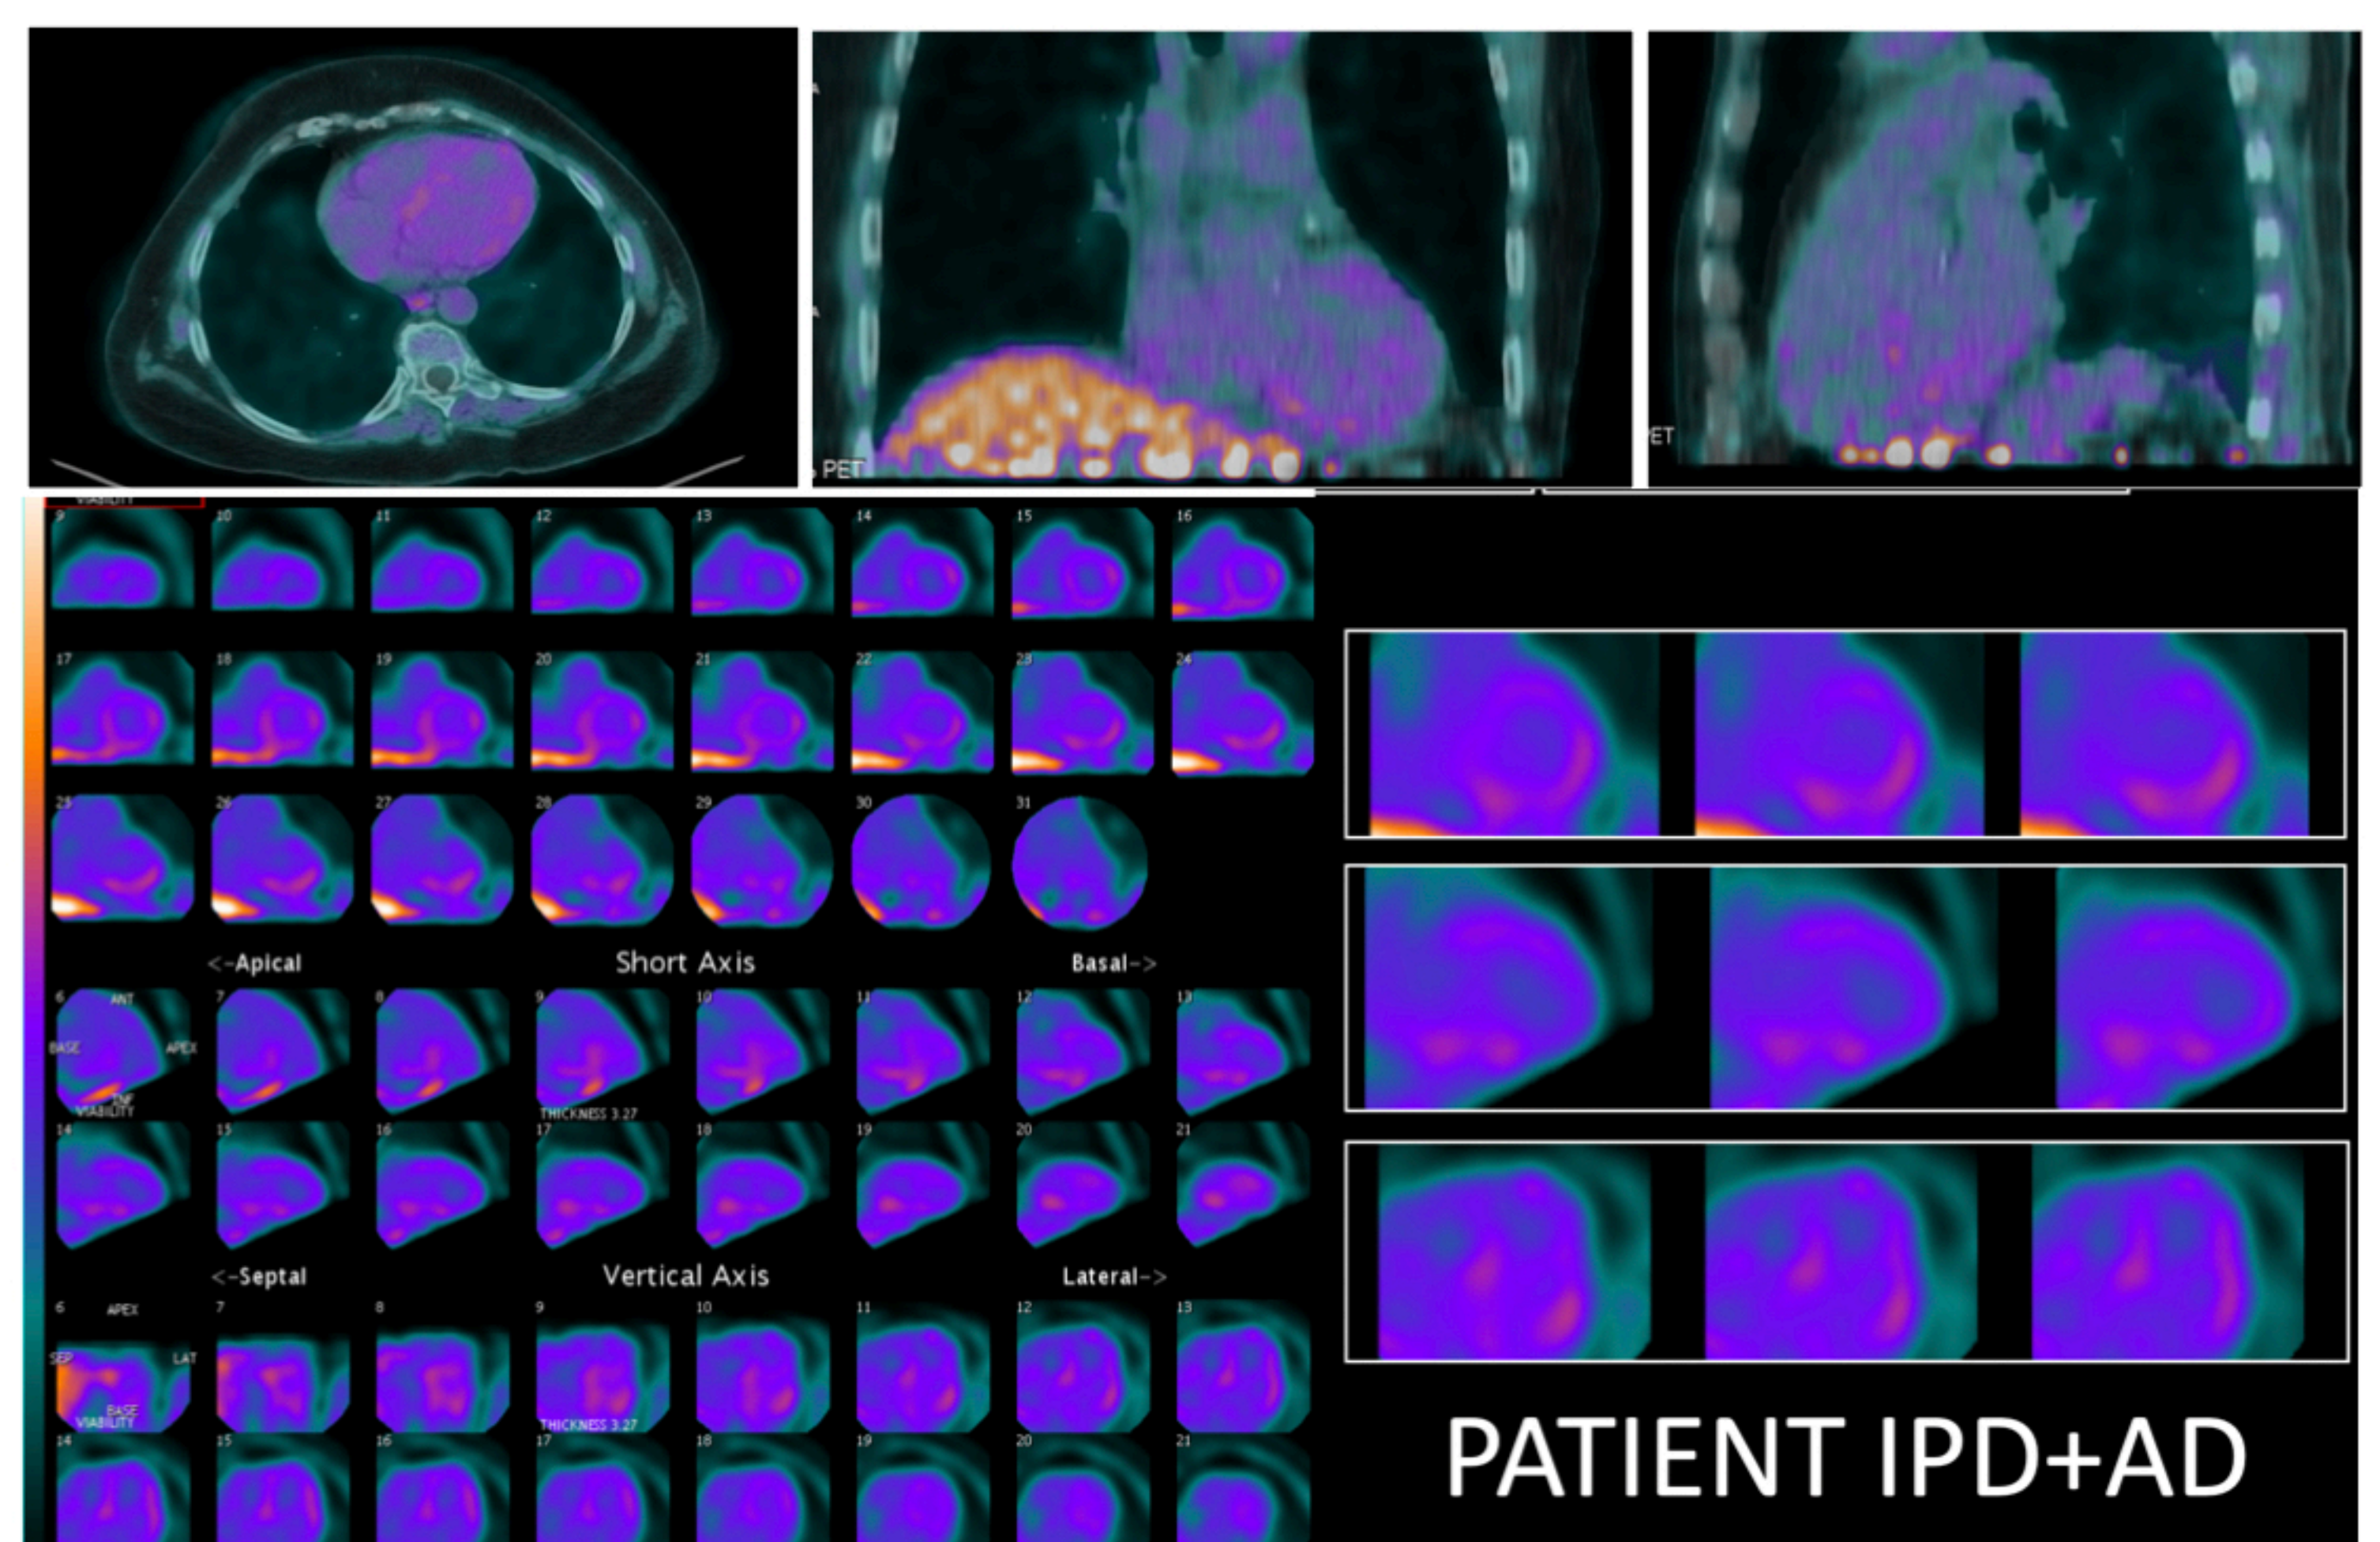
18F-FDOPA PET/CT Cardiac images : there is significantly reduced FDOPA uptake in the entire LV myocardium in the patient with advanced IPD with proven cardiac autonomic dysfunction (AD).
